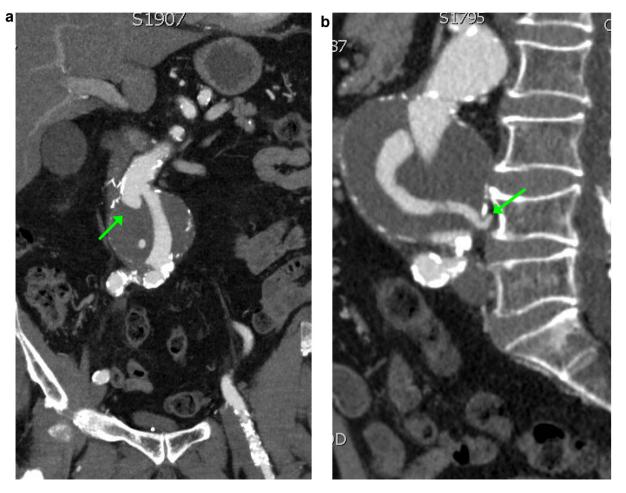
(a) Computed tomography angiogram (CTA), coronal reconstruction view, showing Type Ia endoleak filling aneurysmal sac. (b) CTA sagittal reconstruction view demonstrating the type Ia endoleak associated with an outflow through a patent lumbar vessel (green arrow) that potentially will cause a type II endoleak.
